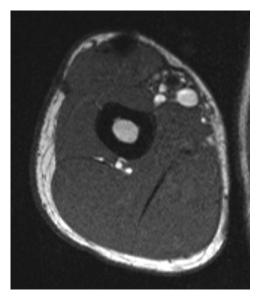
A coronal magnetic resonance image 1 year after surgery demonstrates the intact biceps brachii muscle belly.
